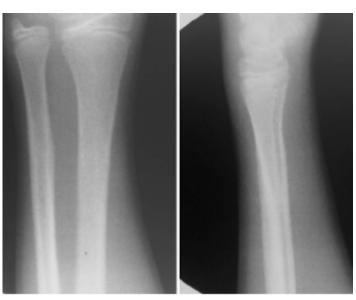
to C. Xrays of the child in Figure 3 which was managed without realignment of the bones. This is an example of bone remodelling in children
